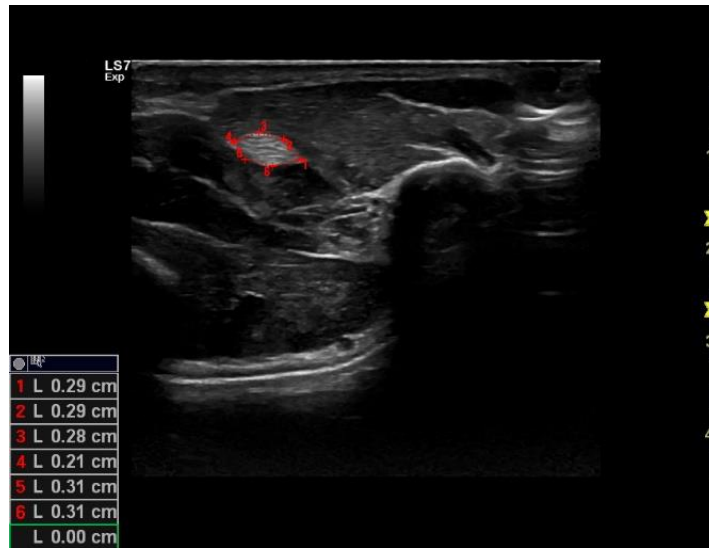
The circumference determination of the flexor pollicis longus tendon at transverse plane (one ultrasound image snapshot) is shown manually. This circumference was evaluated in cm by gathering small straight distances around the cross section of the tendon. The circumference in this evaluation was 1.69 cm
